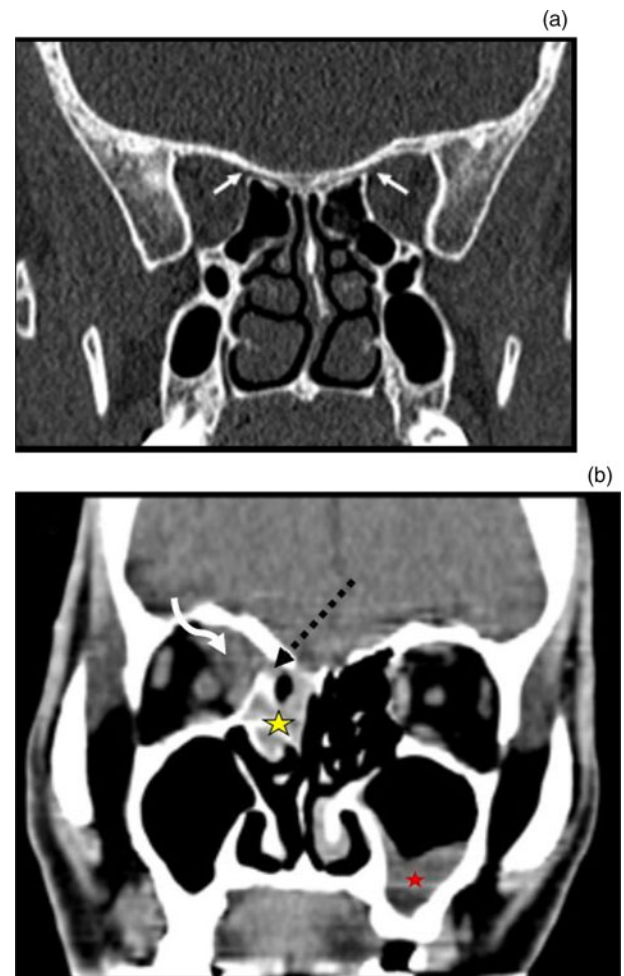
(a) Coronal reformatted computed tomography (CT) image at bone window settings, showing normal anterior ethmoidal foramina (white arrows). (b & c) Contrast-enhanced coronal reformatted CT images at soft tissue and bone window settings in a patient with coronavirus disease 2019 associated mucormycosis, depicting thickening in left anterior ethmoidal air cells (yellow star), extending into the superomedial extraconal compartment of the orbit via the anterior ethmoidal foramen (black arrows), with involvement of the superior oblique muscle (curved white arrow).
